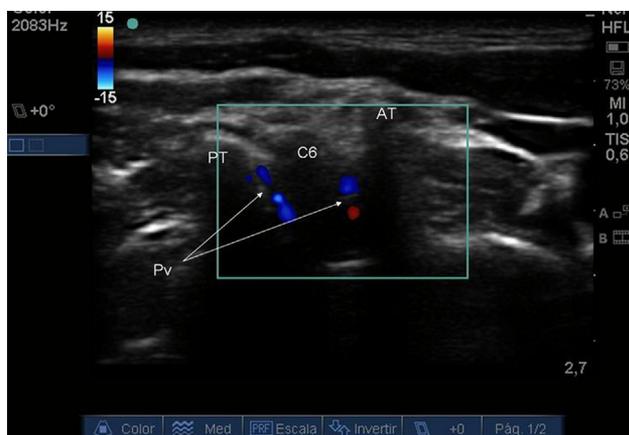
Short-axis transverse ultrasound image with color Doppler showing a small vessel (Pv) at the intravertebral foramen of C6. AT, anterior tubercle; PT, posterior tubercle, C6, sixth cervical vertebra.
